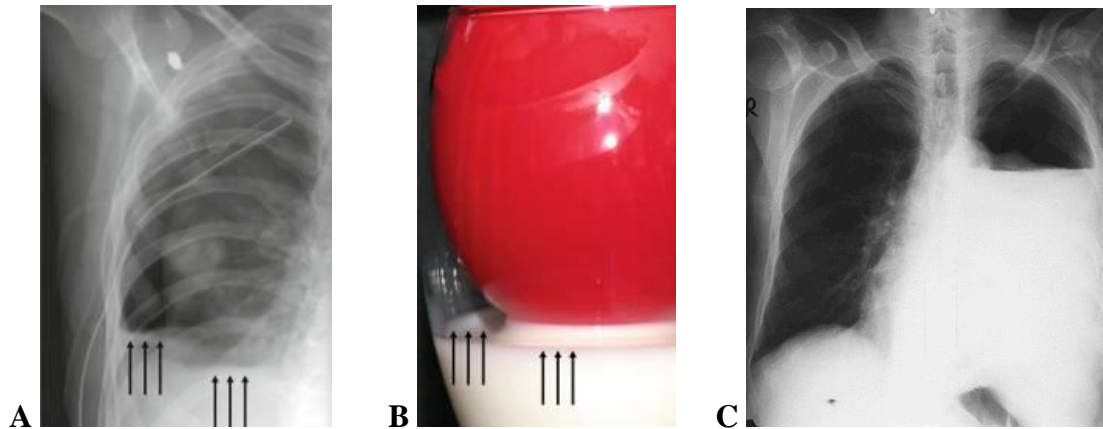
(A) Note similarity with actual hydro-pneumothorax. The arrows demonstrate how fluid level can be perceived in several layers. (B) Balloon analog showing milk layer and partially filled balloon (lung) (representing an erect projection). (C) Frontal chest radiograph, left side large hydro-pneumothorax pushing mediastinum to the right
